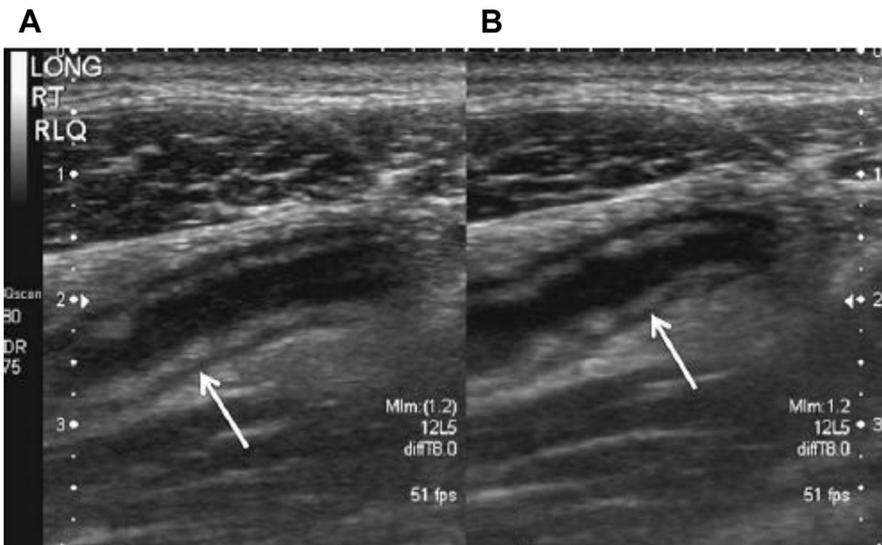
Thickened wall, noncompressible. (A) Sonographic image of appendix without compression. (B) Sonographic image of appendix with compression showing noncompressible appendix. Sonographic image of the thickened wall of the appendix with appendicitis (arrow). (From Parks N, Schroepel T. Update on imaging for acute appendicitis. *Surg Clin North Am* 2011;91:141–54.)
